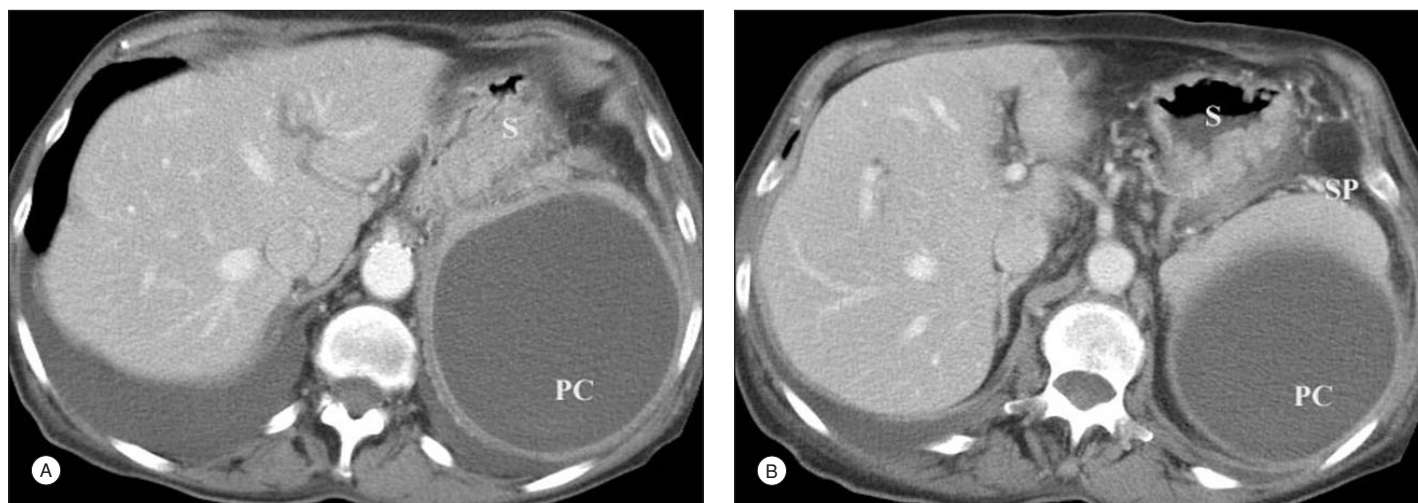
Pancreatic pseudocyst best suited for EUS drainage. A. CT showing a pancreatic pseudocyst (PC) adjacent to the collapsed stomach (S). B. CT scan 1 cm below the previous image. Note the spleen (SP). The narrow window would make attempted non-EUS-guided transmural drainage of this pseudocyst dangerous.
